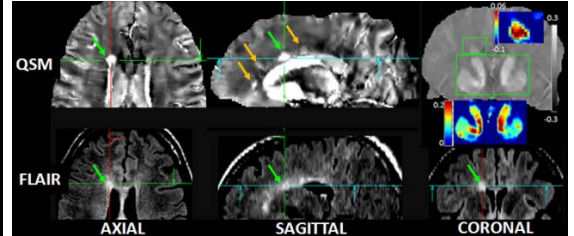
QSM showing clearly delineated lesion boarder compared with faint lesion shown on FLAIR, both on original axial and the reformatted sagittal views (green arrows) with additional lesions visible on the sagittal QSM (orange arrows). The susceptibility distribution with the lesion and basal ganglia are displayed on right.
